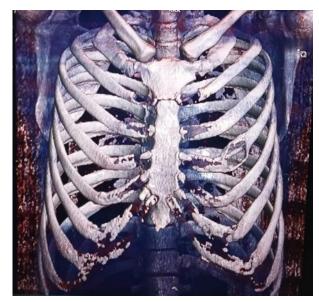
CT scan Thorax 3D
